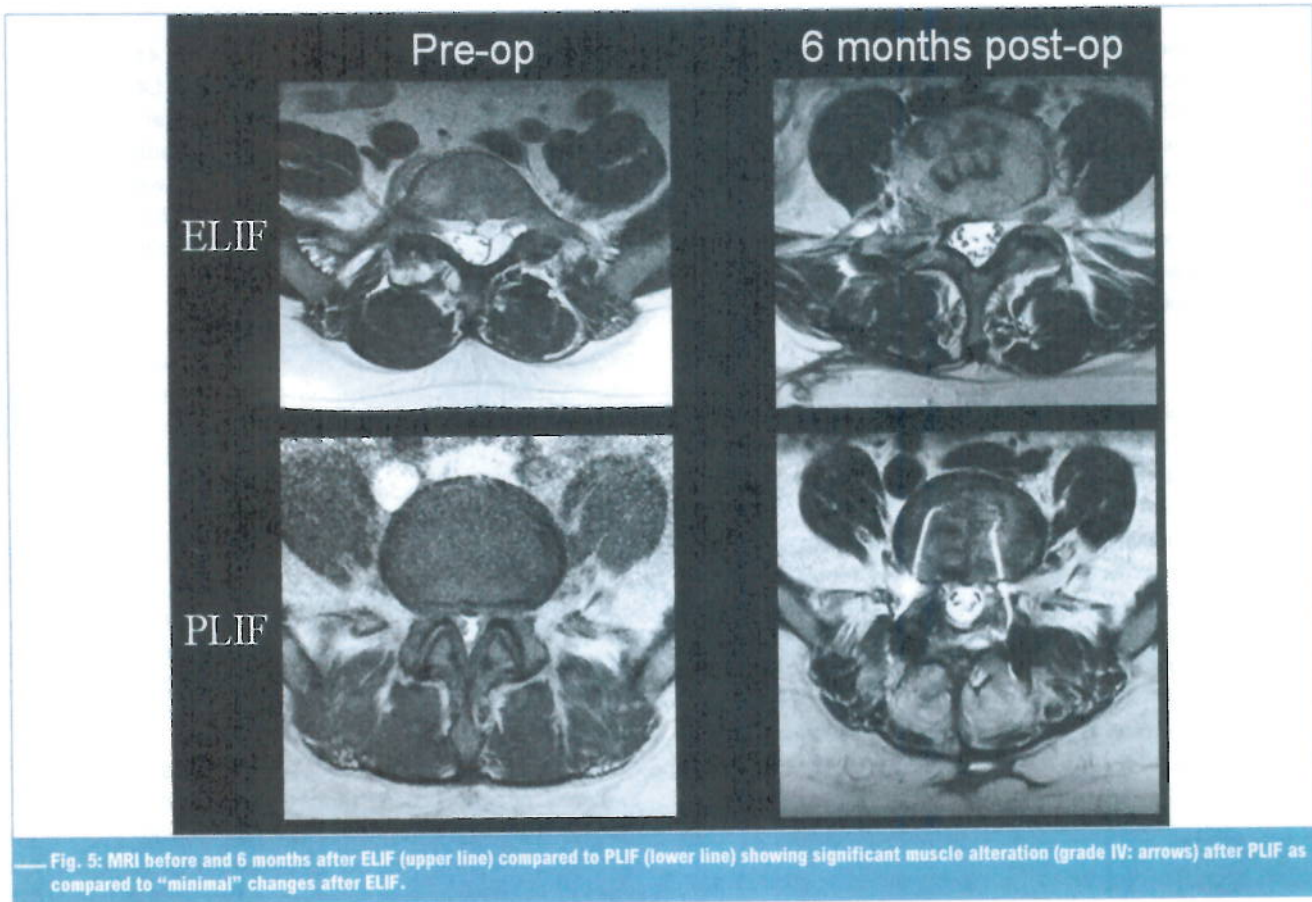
MRI before and 6 months after ELIF (upper line) compared to PLIF (lower line) showing significant muscle alteration (grade IV; arrows) after PLIF as compared to "minimal" changes after ELIF.
